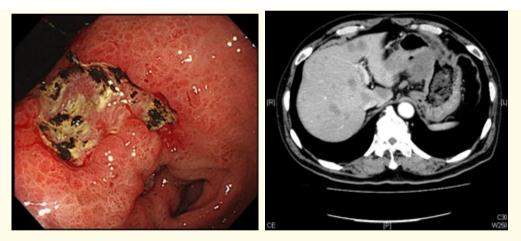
(a) In January 2016, esophagogastroduodenoscopy reveals irregular ulceration on the lesser curvature from the angle to the antrum, involving the location of the original endoscopic submucosal dissection scar. (b) Computed tomography shows a thickened gastric wall, multiple enlarged lymph nodes, including those near the lesser curvature, and multiple liver metastases.
